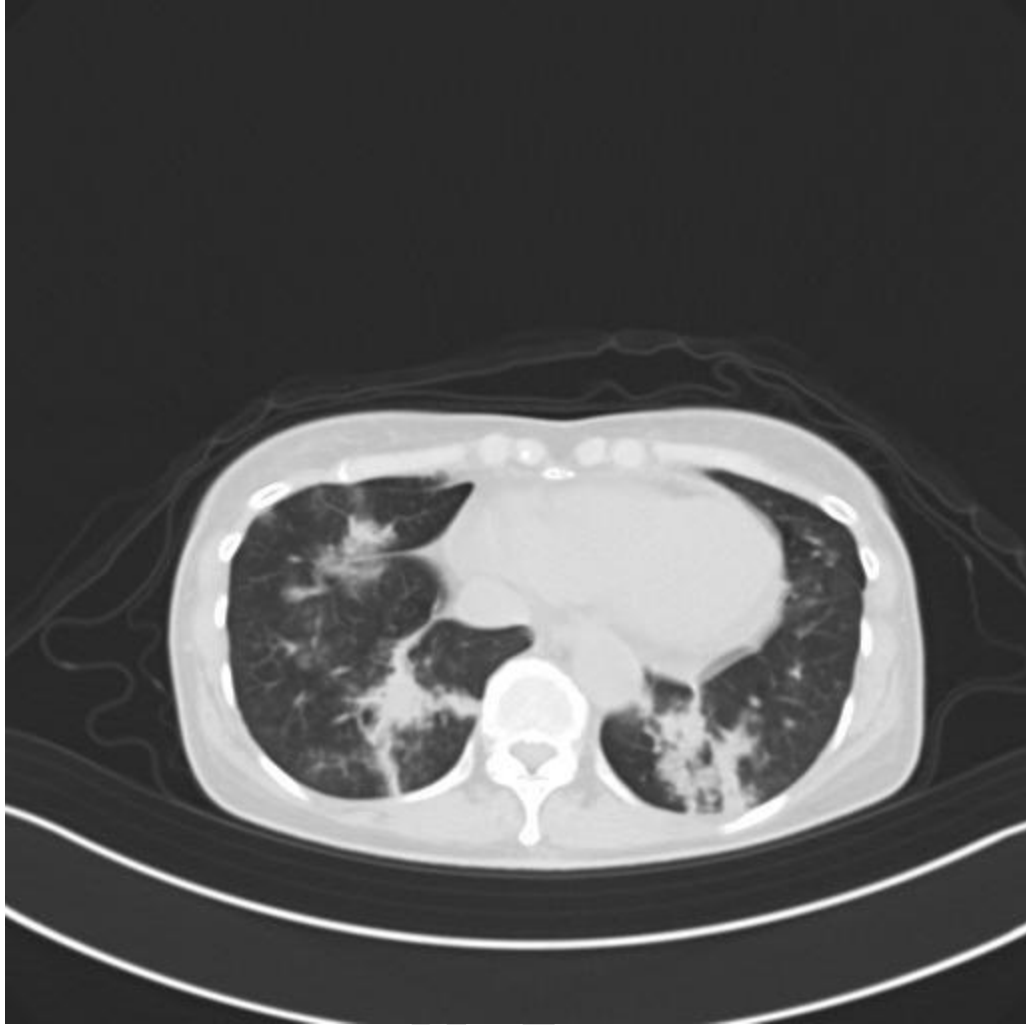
Chest CT revealed bronchiectasis in the both lungs.
